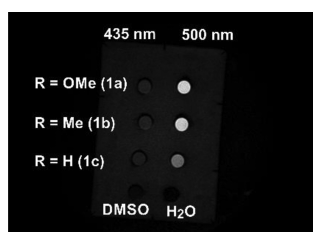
3 T magnetic resonance image of 3 mM solutions of 1a–c irradiated with 435 and 500 nm light. For details, see the SI.
